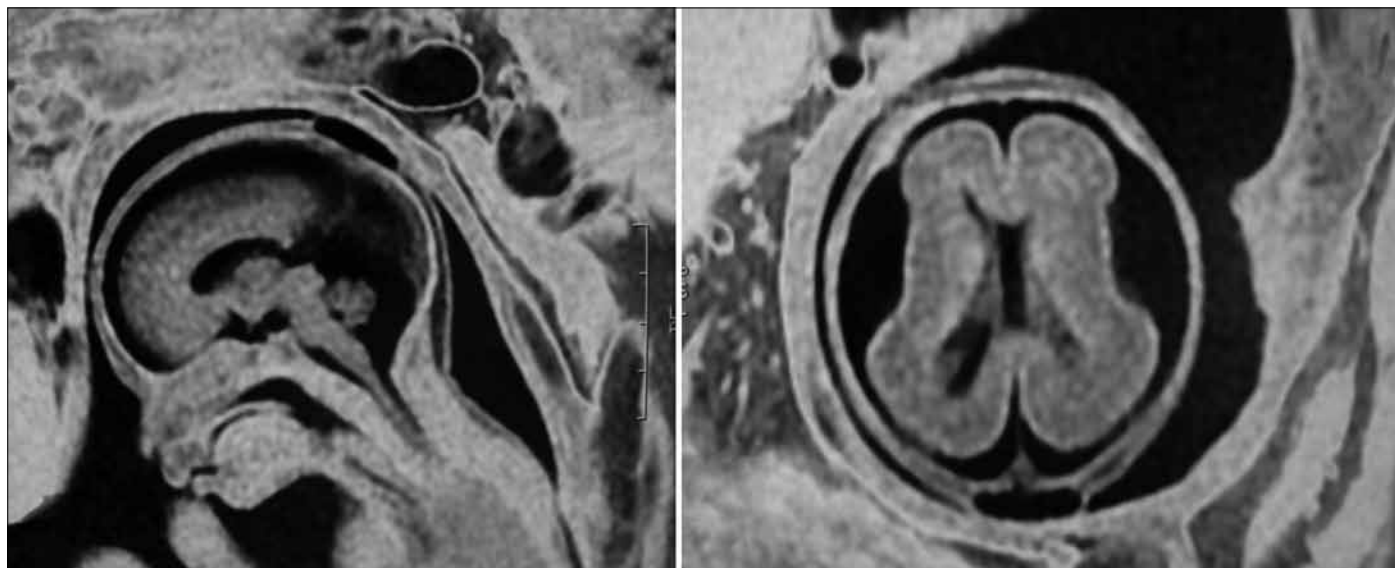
Fetal cranial MRI
